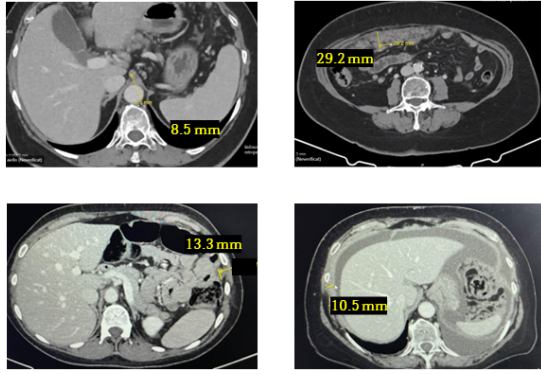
In these CT scans, 4 different patients with OC are depicted, each presenting unique diagnostic challenges. The first patient's scan identifies a discrete retroperitoneal lymph node measuring 8.5 mm. The second patient has a conspicuous omental cake, which is considerably larger at 29.2 mm. For the third patient, a 13.3 mm nodule is present. Lastly, the fourth patient's scan shows peritoneal thickening of 10.5 mm, raising concerns about potential peritoneal carcinomatosis. Each case demonstrates the diverse presentations of OC and the inherent challenges in predicting TR preoperatively.
